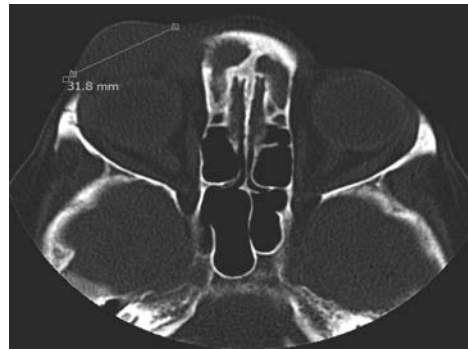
CT (Coronal view) Demonstrating the 3.2 cm Potts Puffy Tumour.
